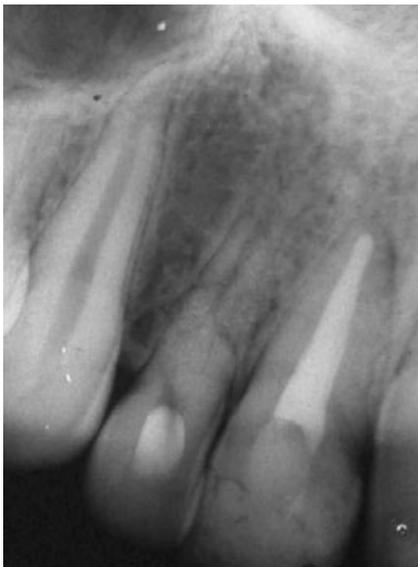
Radiograph taken at 4 years (November 94).
